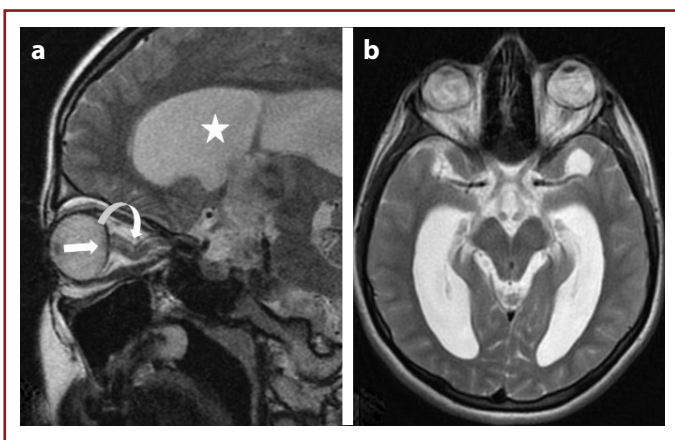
(a) shown that, enlargement of the optic nerve sheath, kinking of the optic nerve (curved arrow), flattening on the scleral surface of the optic nerve (straight arrow) and dilated lateral ventricles (star) on T2-weighted sagittal orbit MRI. (b) shown the dilated lateral ventricular trunk and temporal horns on T2-weighted axial cranial MRI of the 12-year-old patient.
